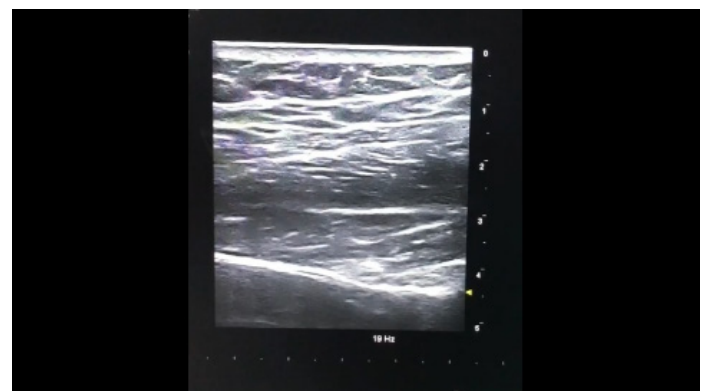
Anatomical structures observed in the intervention of the suprascapular nerve in ultrasound imaging.
